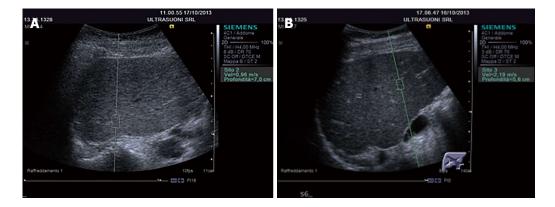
The region of interest of acoustic radiation force impulse speed is positioned in the right lobe of the liver, with an intercostal scan performed with the help of ultrasound B-mode (A and B). On the right of the display there is the depth at which the measurement is performed and acoustic radiation force impulse (ARFI) speed measurement. In panel A subject with normal ARFI speed value (expressed in m/s). In panel B patient with ARFI speed value (expressed in m/s) compatible with liver cirrhosis.
